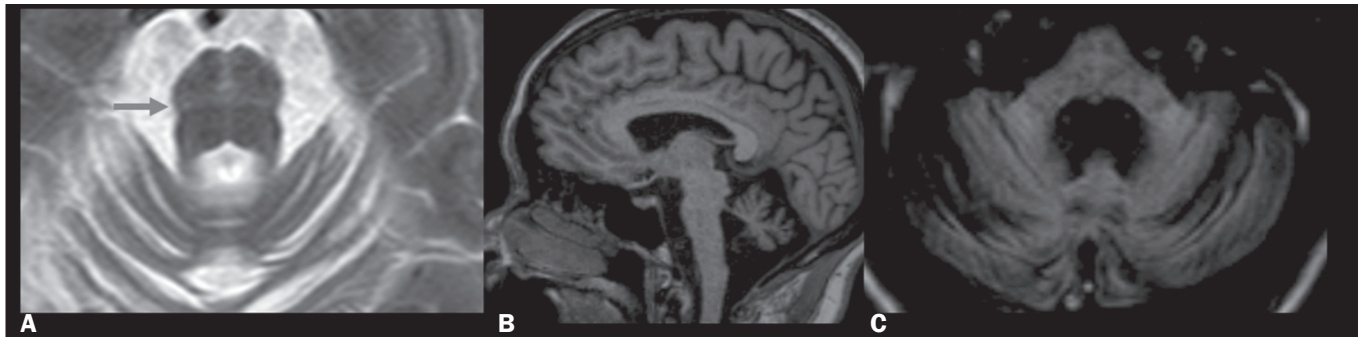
MSA with cerebellar ataxia. A: Axial T2WI showing a hyperintense cross in the form of a hot cross bun. B: Sagittal T1WI showing flattening of the anterior aspect of the pons and cerebellar atrophy. C: Axial FLAIR sequence showing cerebellar and MCP atrophy, together with hyperintensities in the MCPs.
